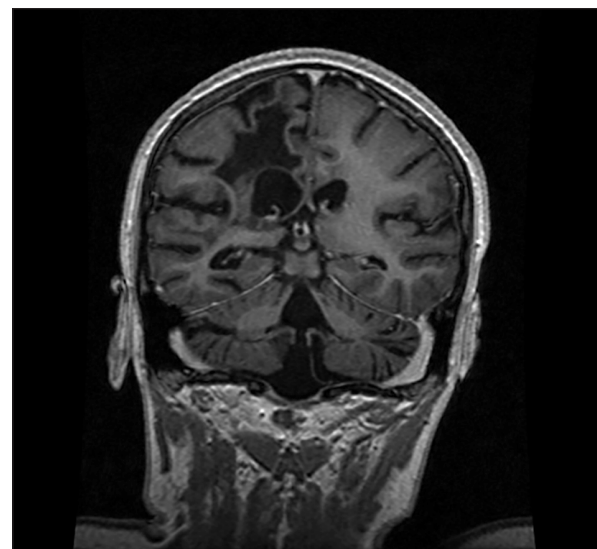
Cerebral MRI – isointense T1-weighted area of the left semioval center smaller than the isointense T1-weighted area in the right hemisphere
